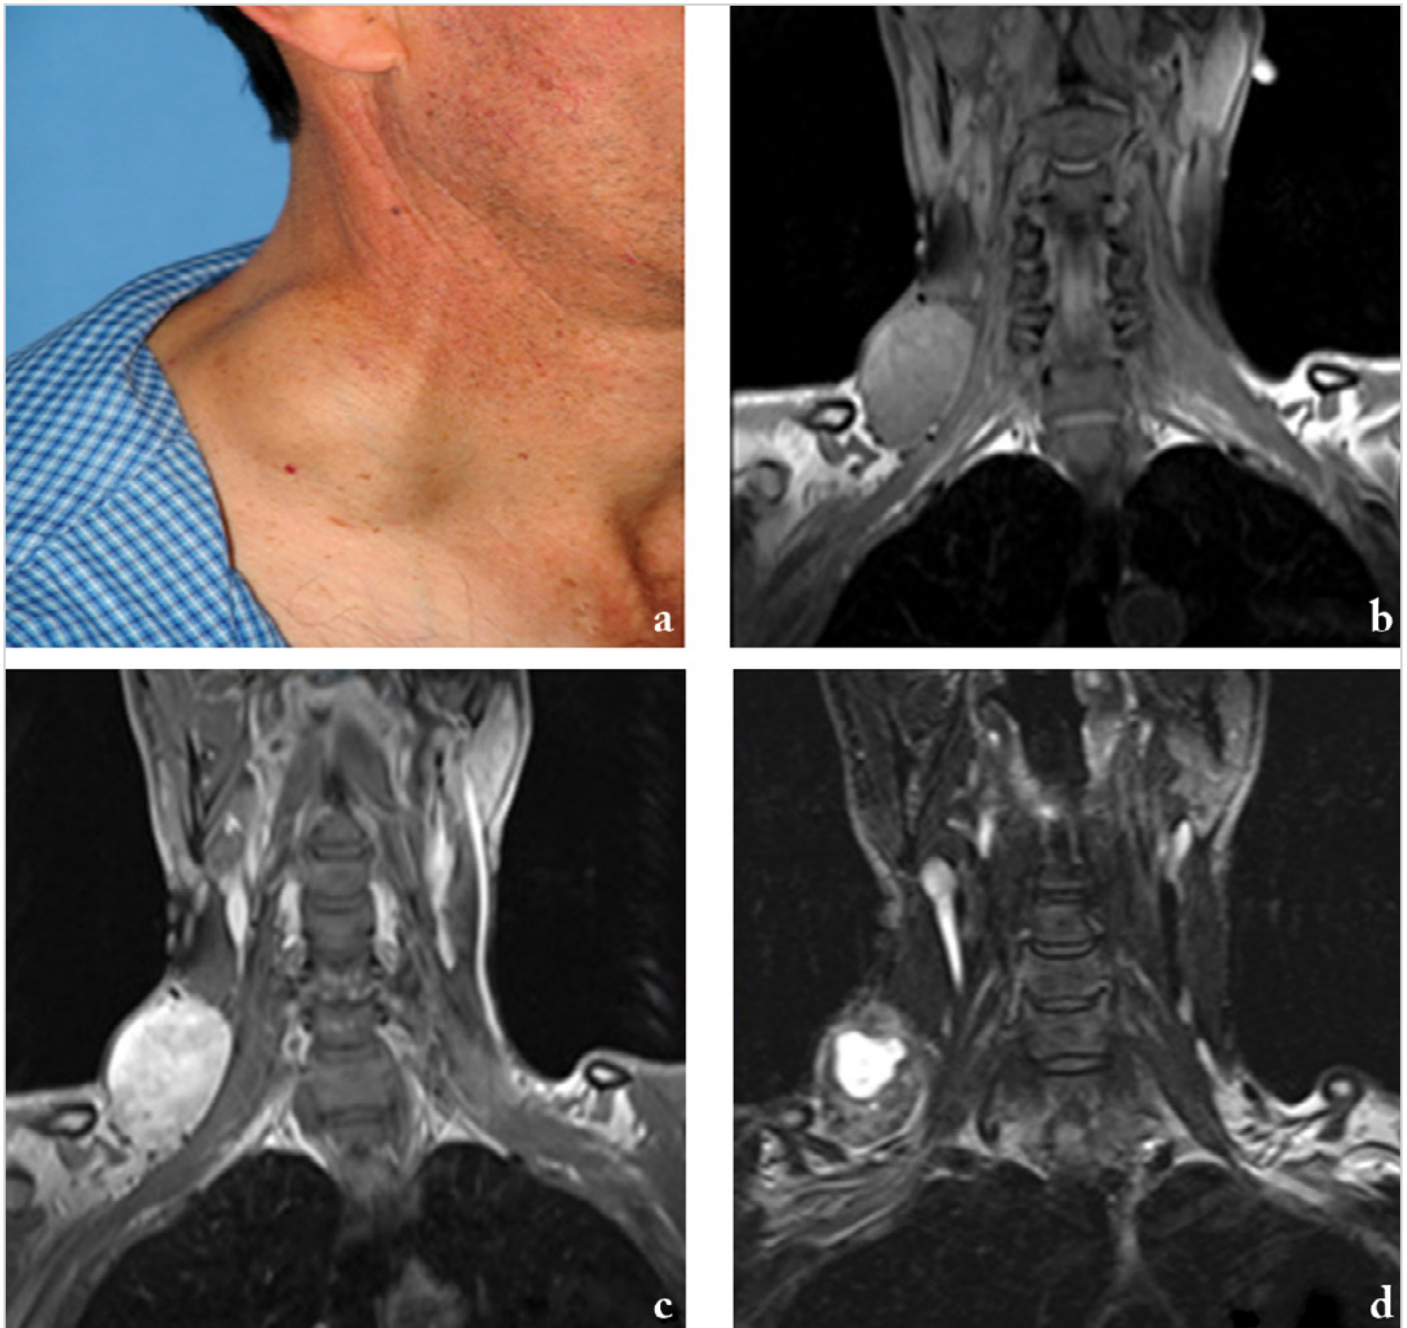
a-d. A soft tissue mass in the right supraclavicular region (a), a supraclavicular solid mass in the precontrast T1-weighted coronal MRI image (b), heterogeneous involvement of supraclavicular solid mass in postcontrast T1-weighted coronal MRI image (c), central hyperintensity in the supraclavicular solid mass in T2-weighted coronal MRI image (d)
